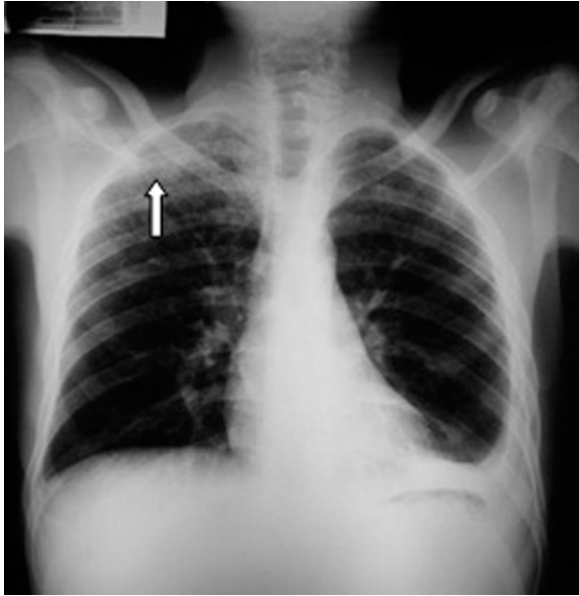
Postero-anterior chest X-ray showing pulmonary infiltrate in the apex of the right lung.
